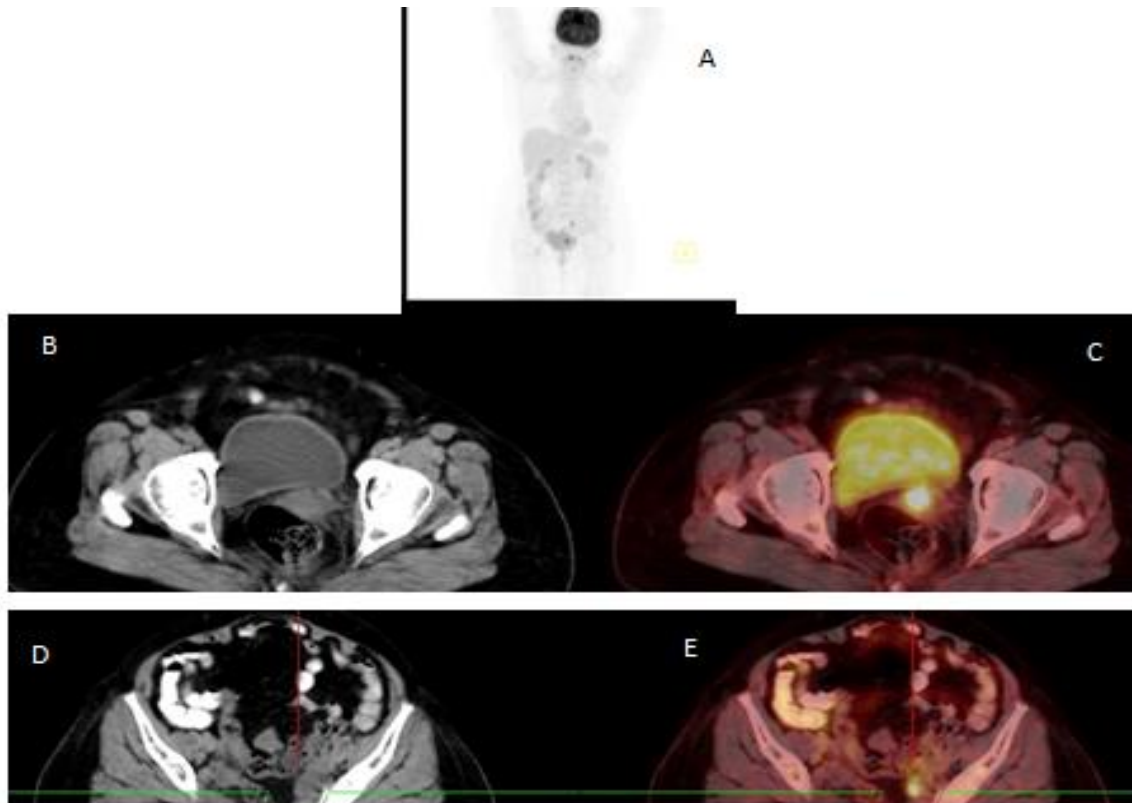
Maximum intensity projection image(A). CT axial image(B) and fused PET-CT image(C) Showing intense FDG uptake in cervix. CT axial image(D) and fused PET-CT image(E) showing intense FDG uptake in left external iliac lymphnode.
